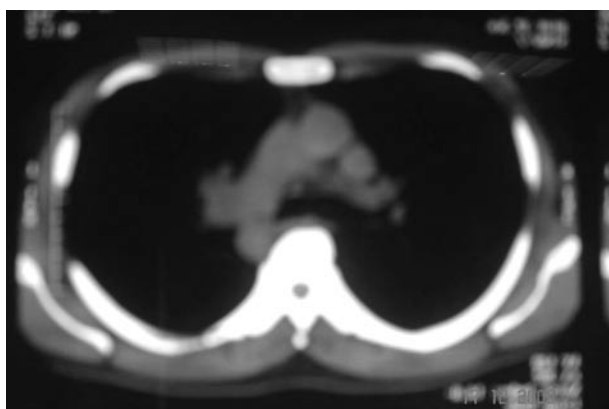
Thoracic CT scan showing mediastinal adenopathy
